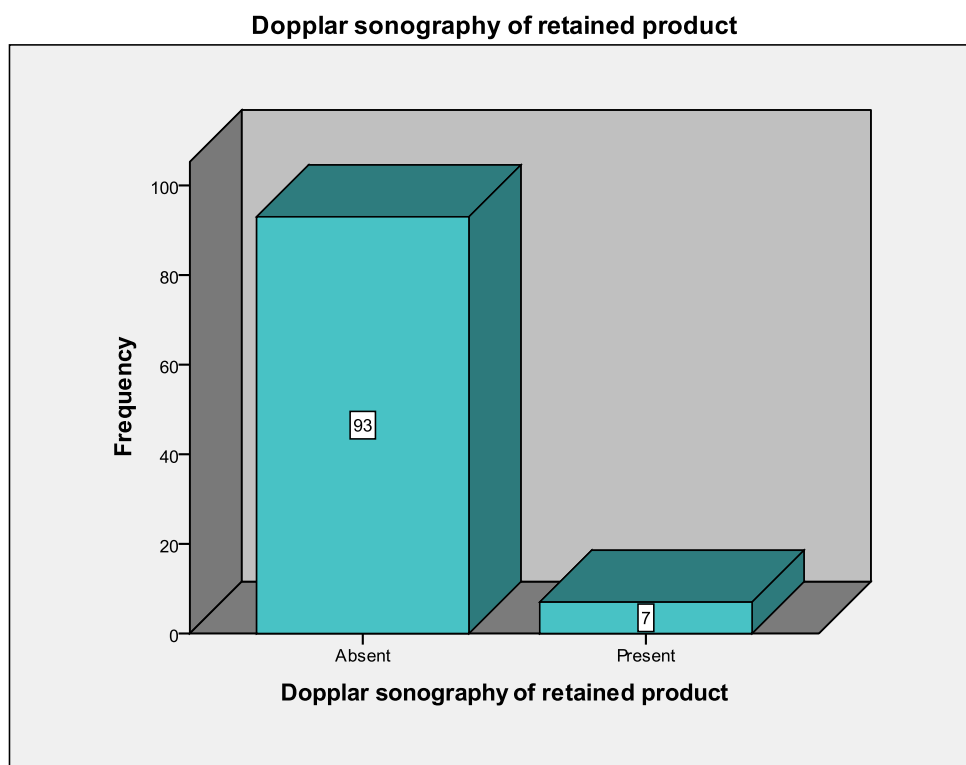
frequency distribution of Doppler sonography of retained product
